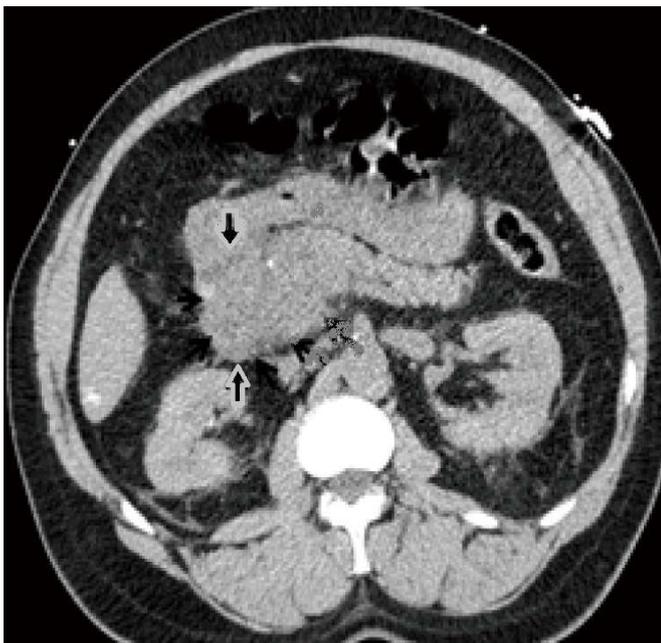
Non-contrast CT scan shows enlargement of pancreatic head and adjacent fat stranding consistent with pancreatitis
